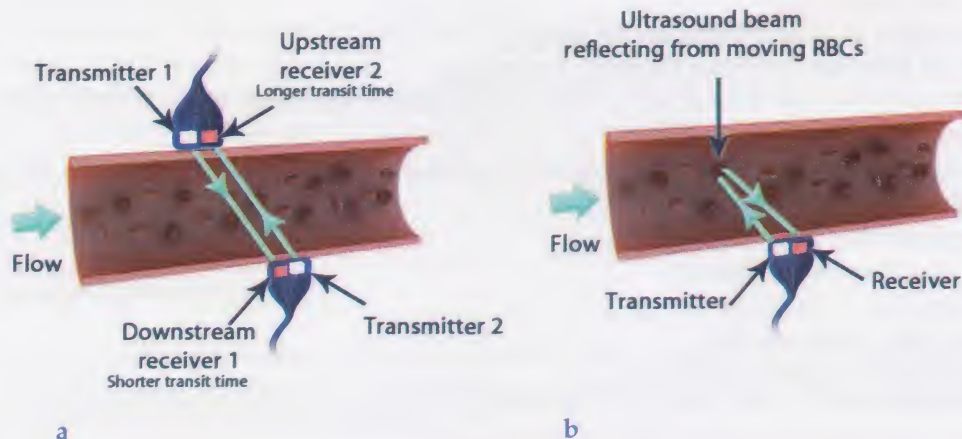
Ultrasonic flowmeter; Transit time (a) and Doppler principle
